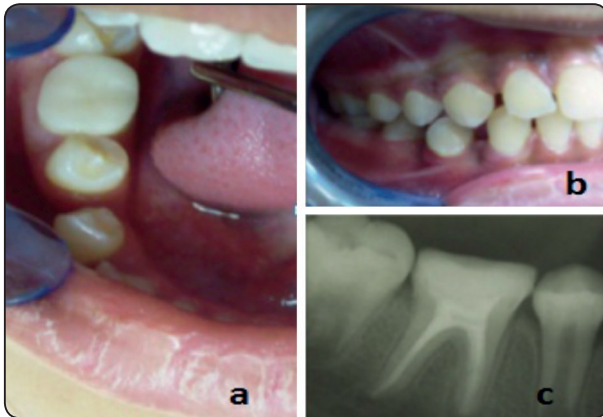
(a) Endocrown immediately after cementation, (b) after 12 month follow-up (c) radiographic examination after 12 months.
